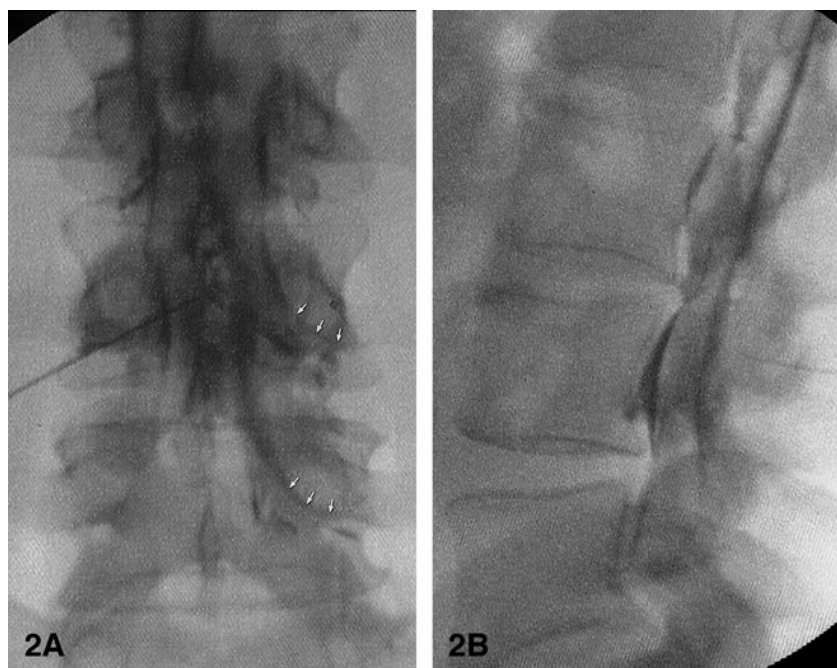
A and B, Anteroposterior (A) and lateral (B) radiographs after contrast injection. The needle is positioned centrally within the dorsal epidural space using technique 1 or 2; the contrast material is seen circumferentially within the epidural space and along the proximal nerve sheaths (arrows).
